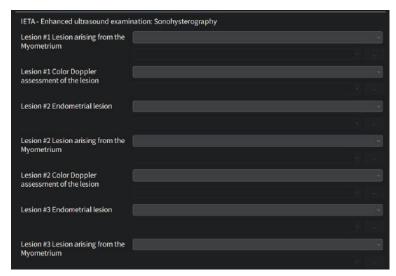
IETA - Enhanced ultrasound examination: Sonohysterography
